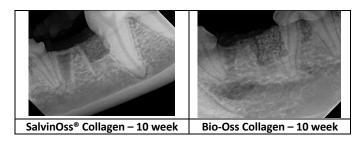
Radiographic Images of SalvinOss® Collagen & Bio-Oss Collagen® at 10 Weeks
